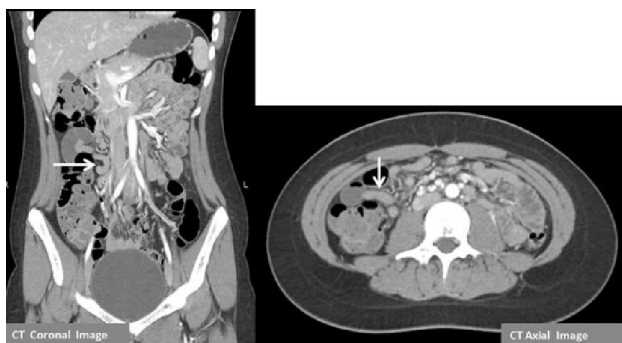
CT scan abdomen (with oral and intravenous contrast enhanced) showing a Meckel's diverticulum as blind loop (arrow) in the right mid abdomen region.
